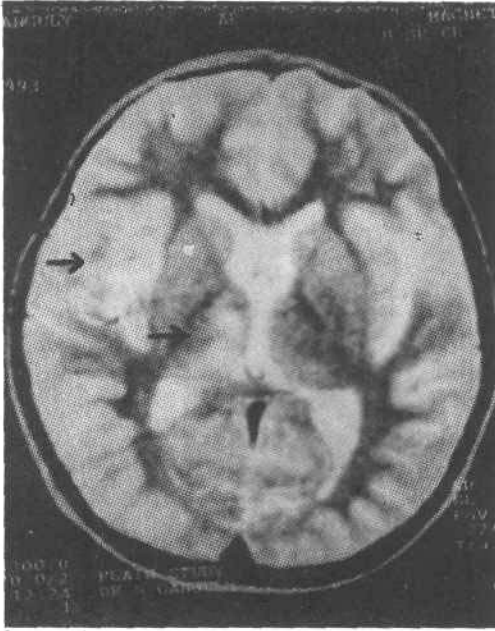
MRI showing hyperintense lesions at the gray white interface in the right parietal region and the right thalamus.
